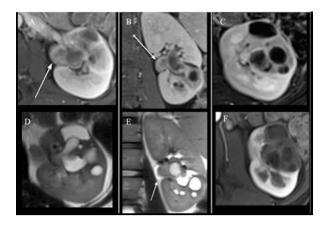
Contrast-enhanced computed tomography (CT) scan (postcontrast sequences): a relatively well defined 4.0 x 3.5 cm predominantly cystic mass with associated mild heterogeneous, delayed enhancement within the septa and solid component on postcontrast sequences in the lower pole (A, B, and C). The mass extends into the renal pelvis and collecting system, causing a filling defect on the excretion series (D). The largest septum measures up to 0.9 cm
